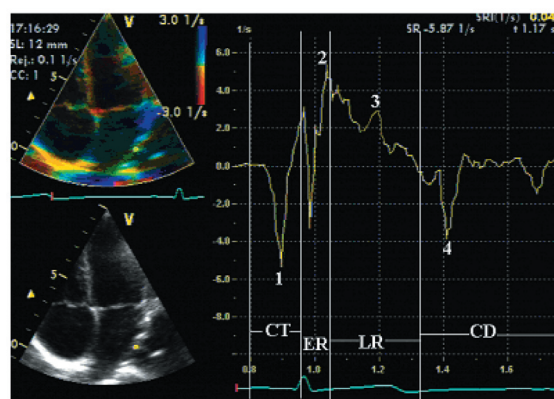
Strain rate curve extracted from the apical 4-chamber view. The CT, R (including ER and LR), and CD phases are shown. Peaks 1, 2, 3, and 4 represent CT-PSR, ER-PSR, LR-PSR, and CD-PSR, respectively.
